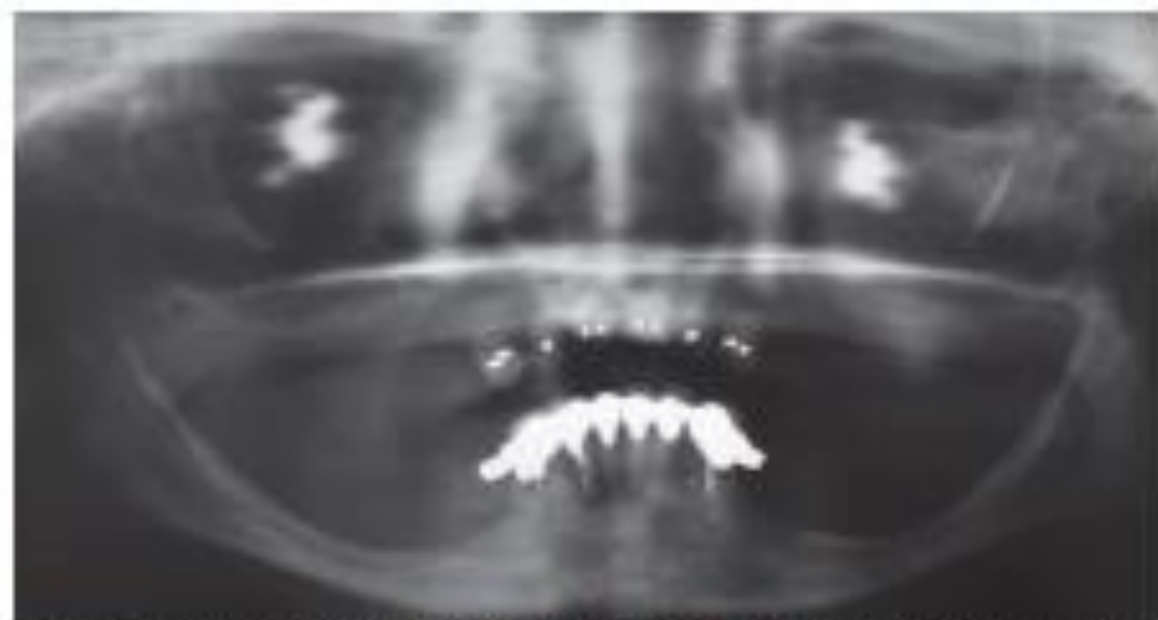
All panoramic radiographs exhibit magnification, distortion, overlapping of images, and ghost images, making these images inaccurate as the sole determination for dental implant diagnosis.
